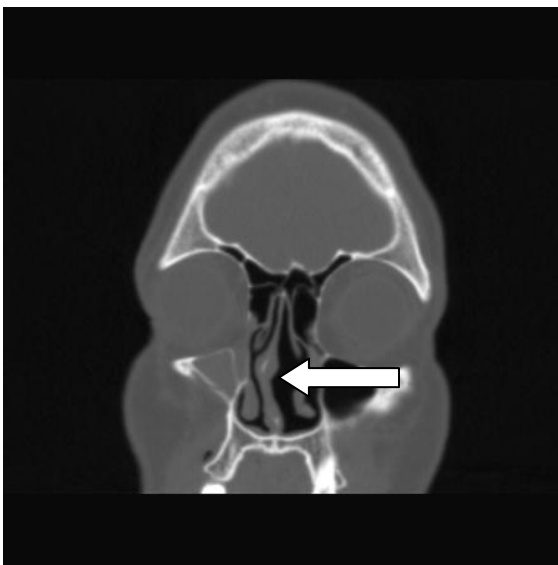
This is a coronal CT scan of the sinuses of another patient demonstrating septal deviation toward the patient’s right side. The ostiomeatal complex is swollen and blocked.
